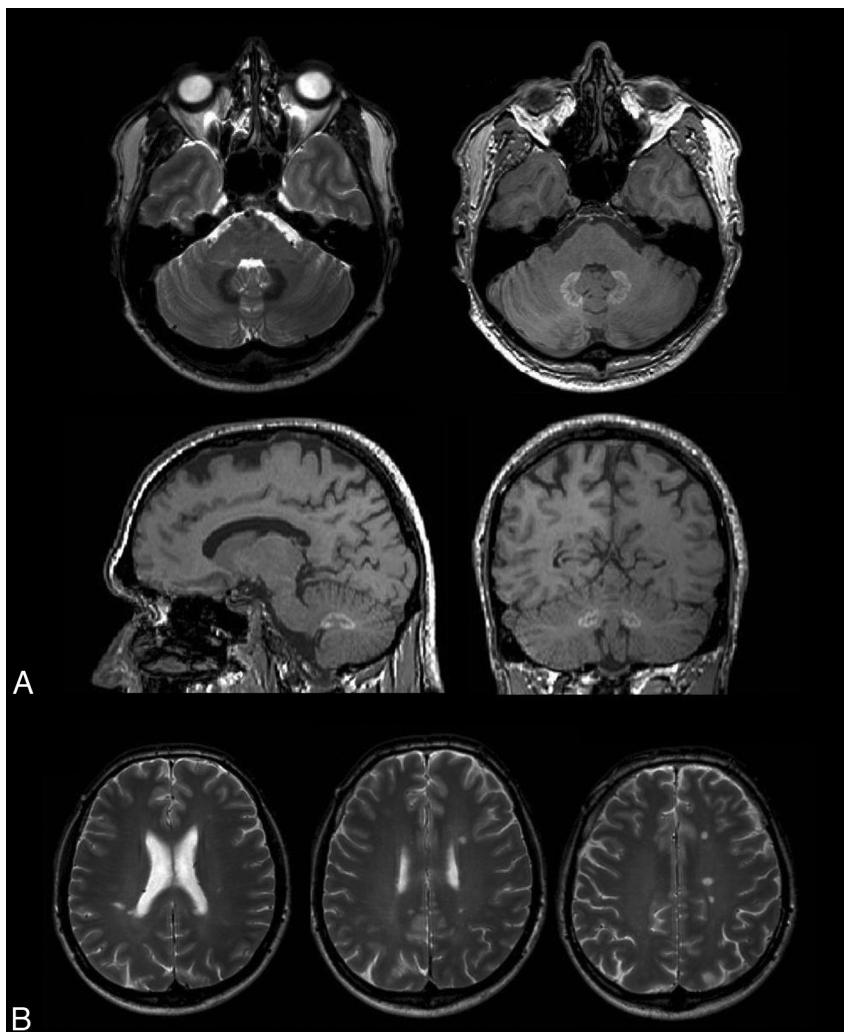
A, Hypointensity on T2-weighted and hyperintensity on unenhanced T1-weighted scans of the dentate nuclei, bilaterally, in a patient with RRMS. B, Multiple hyperintense lesions, mainly located in the periventricular and deep white matter, are visible on the T2-weighted sequence. These findings are congruent with the clinical diagnosis.
